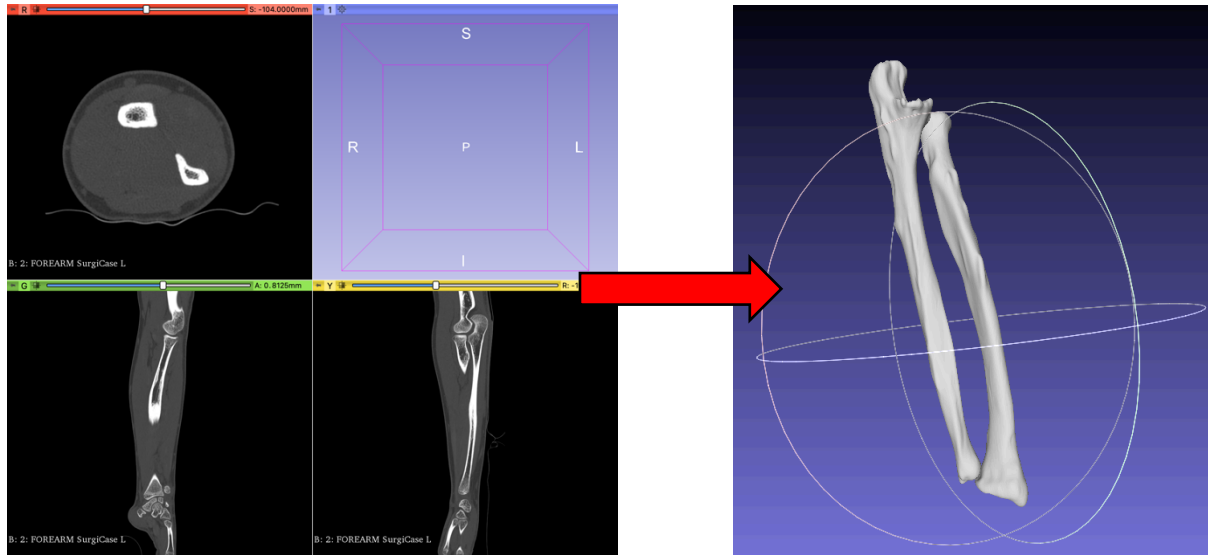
CT scans reconstruction in the 3D Slicer to 3D model
